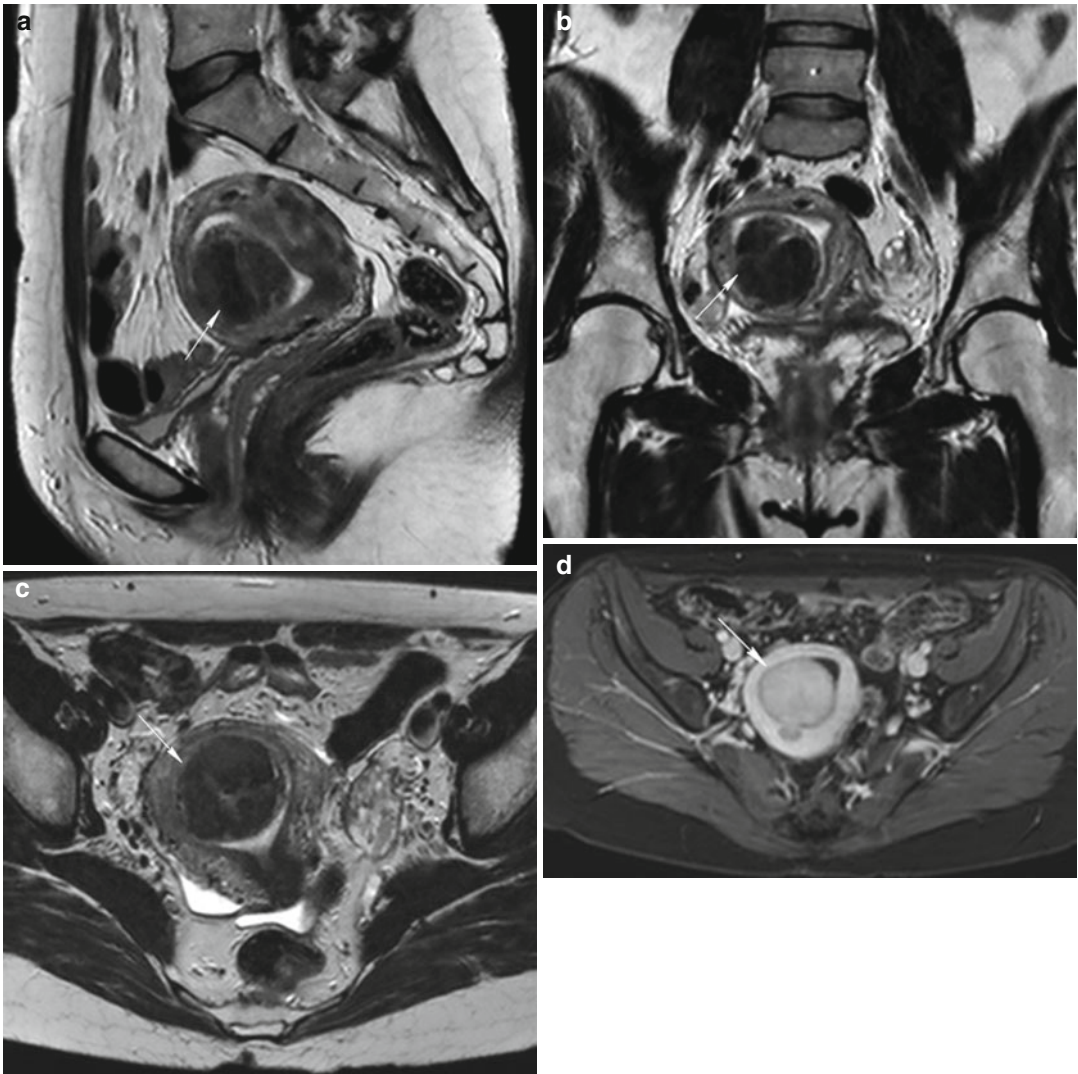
Pedunculated submucosal fibroid (*arrow* in all images). Sagittal (TR 3,400 ms, TE 80 ms) (a), coronal (TR 3,700 ms, TE 100 ms) (b), axial (TR 4,800 ms, TE 120 ms) (c) T2-weighted, and axial contrast-enhanced fat-suppressed T1-weighted (TR 4 ms, TE 2 ms) (d) images
